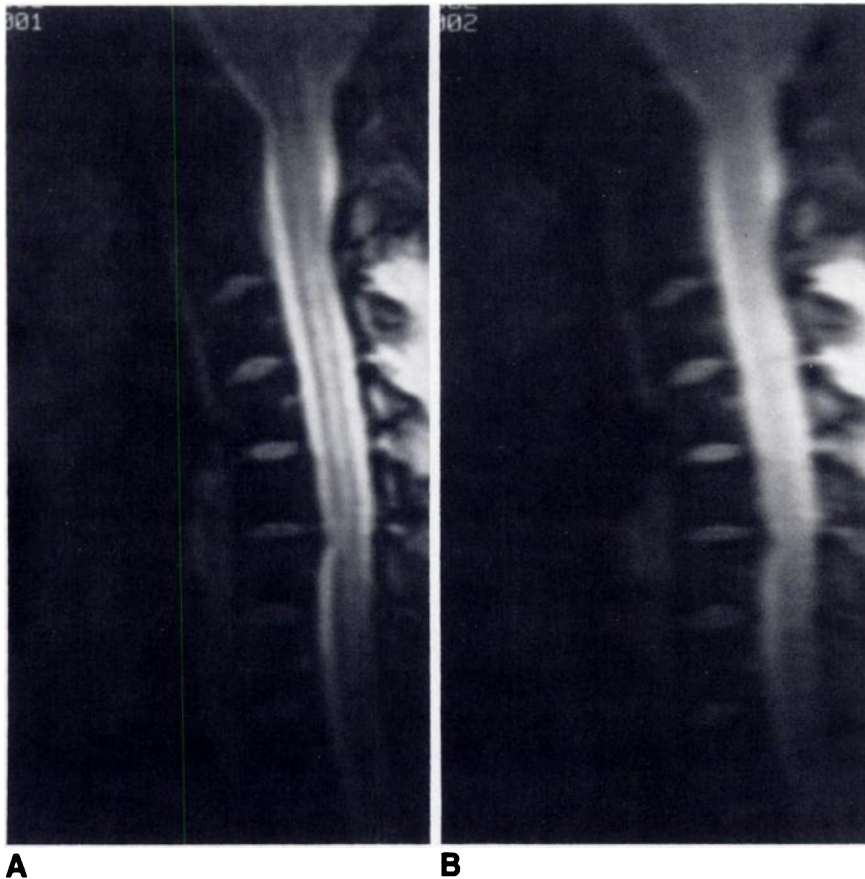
Effect of filtering on MR imaging. Sagittal images, 2000/20, of cervical spine with 256 × 256 matrix and cardiac gating.
